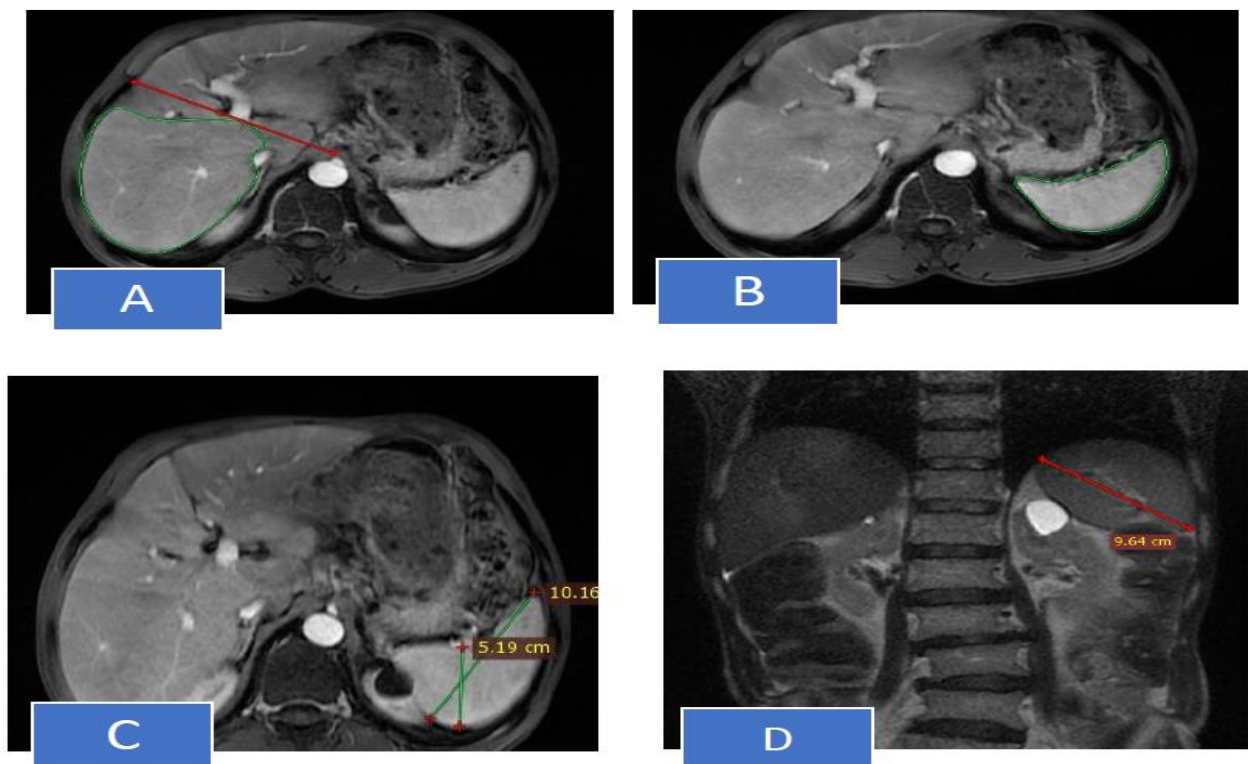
A 57-year-old patient with hepatitis c viral history and cirrhosis of the liver, and no history of hepatic encephalopathy and esophageal varices, or ascites. His platelet count was $200 \times 10^9/l$, albumin level was 3.3 g/dl, bilirubin was 0.6 mg/dl, and the prothrombin time was 14 sec, so the Child-Pugh score was 6 (class A). A: Outline of the right liver lobe (in green) was delineated on the axial enhanced magnetic resonance image portal phase. B: Outline of the spleen (in green) was improved (magnetic resonance imaging portal phase delineation). C: Spleen maximal width and maximal thickness on axial enhanced magnetic resonance image. D: Spleen maximal length on coronal cut magnetic resonance image. Findings: Spleen volume = 323.3, Spleen volume/platelet count = 1.62, Spleen index = spleen maximal width (W) x thickness (T) x length (L) = 505.68, Spleen index/platelet count = 2.53, RT liver volume = 843.51, RVPS = Rt liver vol x plt count / spleen volume = 521.81. The patient had no EV and low Child Pugh score (6), so SI/PL and SV/PL decreased, while RVPS increased.
